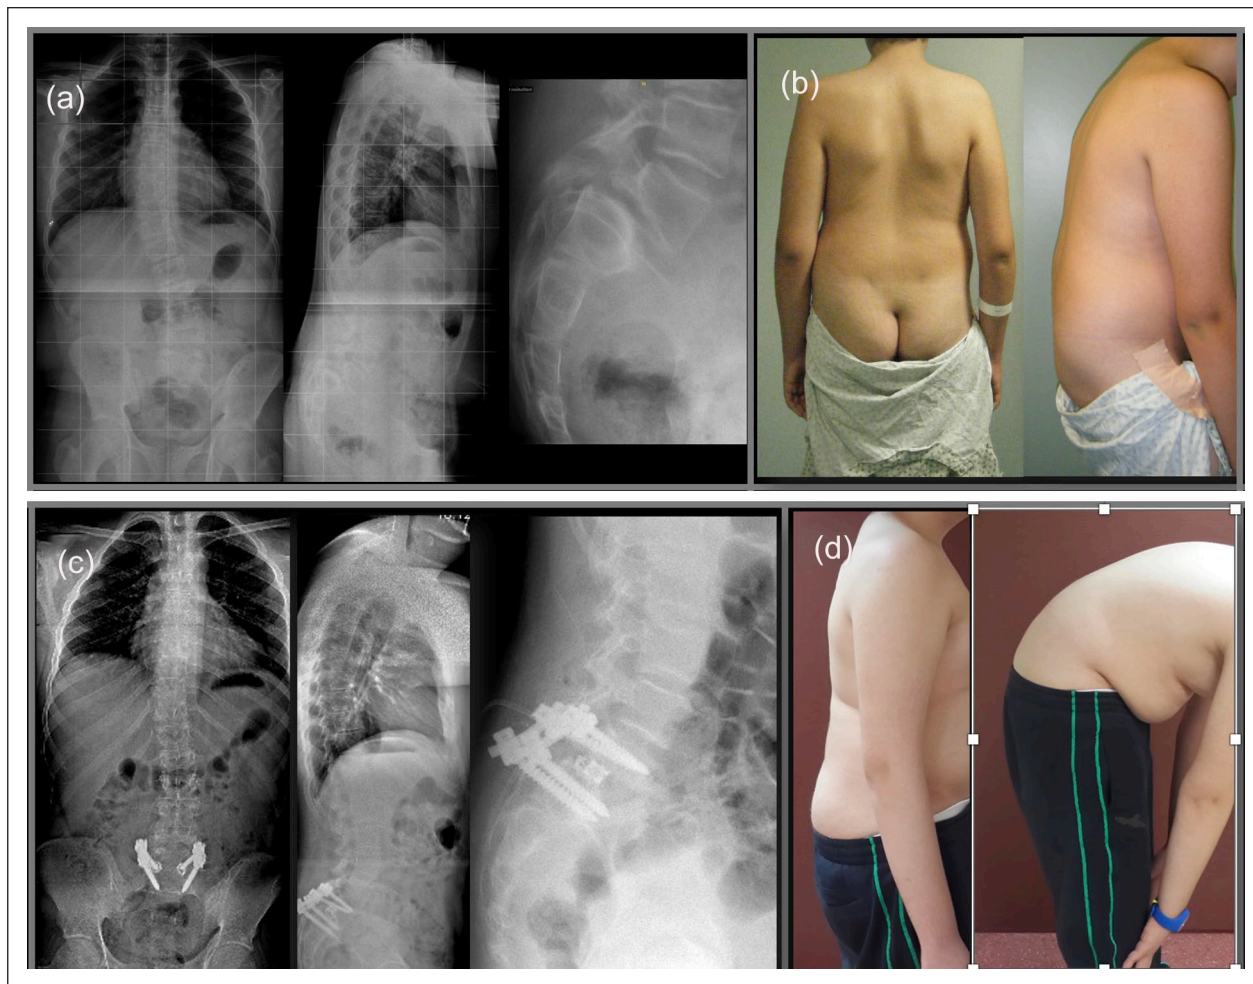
Radiographs (a) and clinical photographs (b) of a 16-year-old female patient with high-grade spondylolisthesis. Postoperative radiographs (c) and clinical photographs (d) have been shown, and the patient has been treated with a sacral dome resection followed by reduction and circumferential fusion including TLIF.
